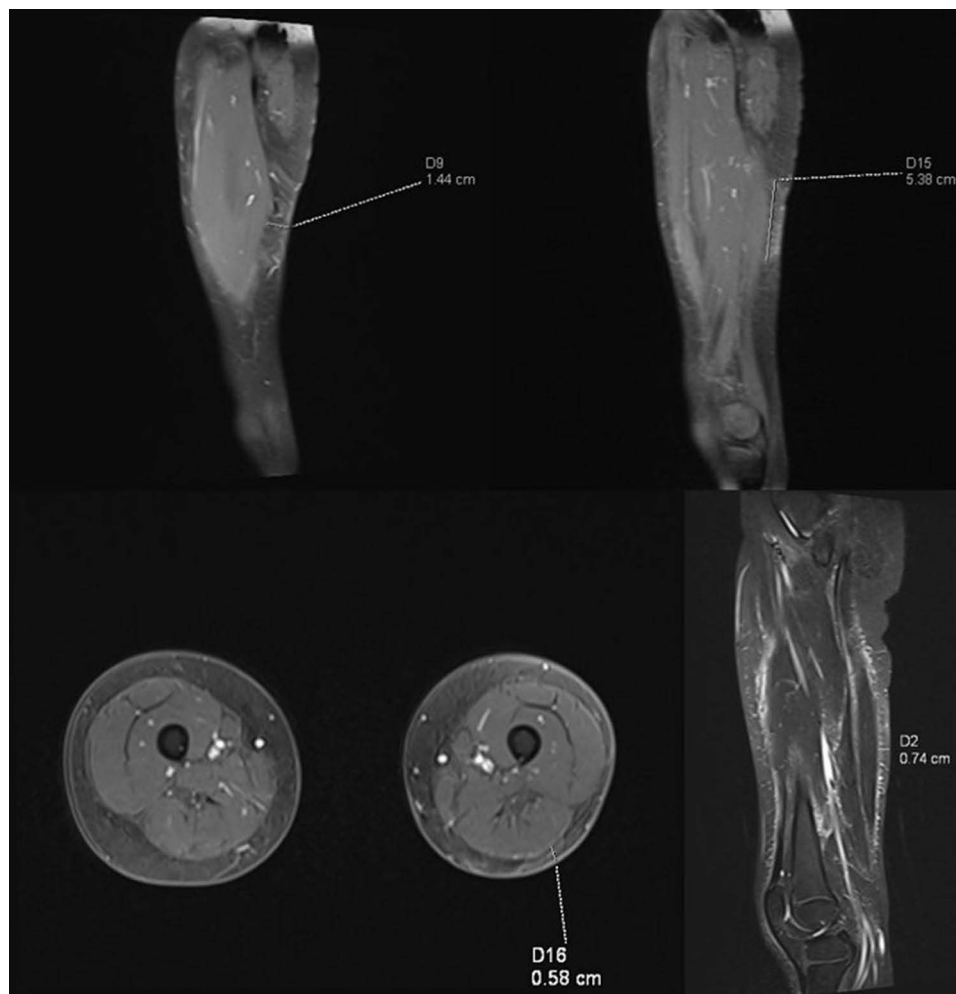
A follow-up MRI showing regression of the primary lesion in one month after the start of therapy. Significant regression of the described lesions of the subcutaneous tissue (24 × 7×60 mm), the nature of residual edema of the subcutaneous tissue. The lesion was measured and marked with a white indicator in the figure.
